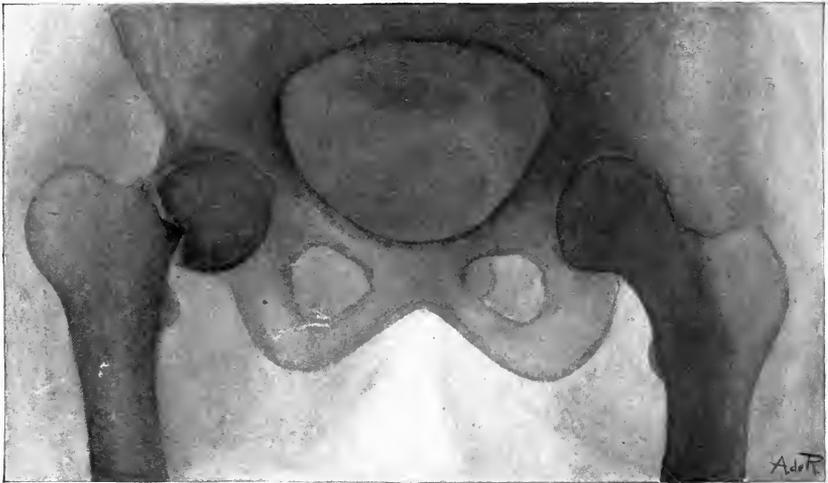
X-RAY OF A FRACTURE OF THE NECK OF THE FEMUR AT THE JUNCTION OF THE HEAD AND NECK, WITH UPWARD DISPLACEMENT OF THE SHAFT OF THE FEMUR. On the opposite side note the outlines of the normal femur and hip-joint. This x-ray was kindly loaned by Dr. Le Moyne Wills.
